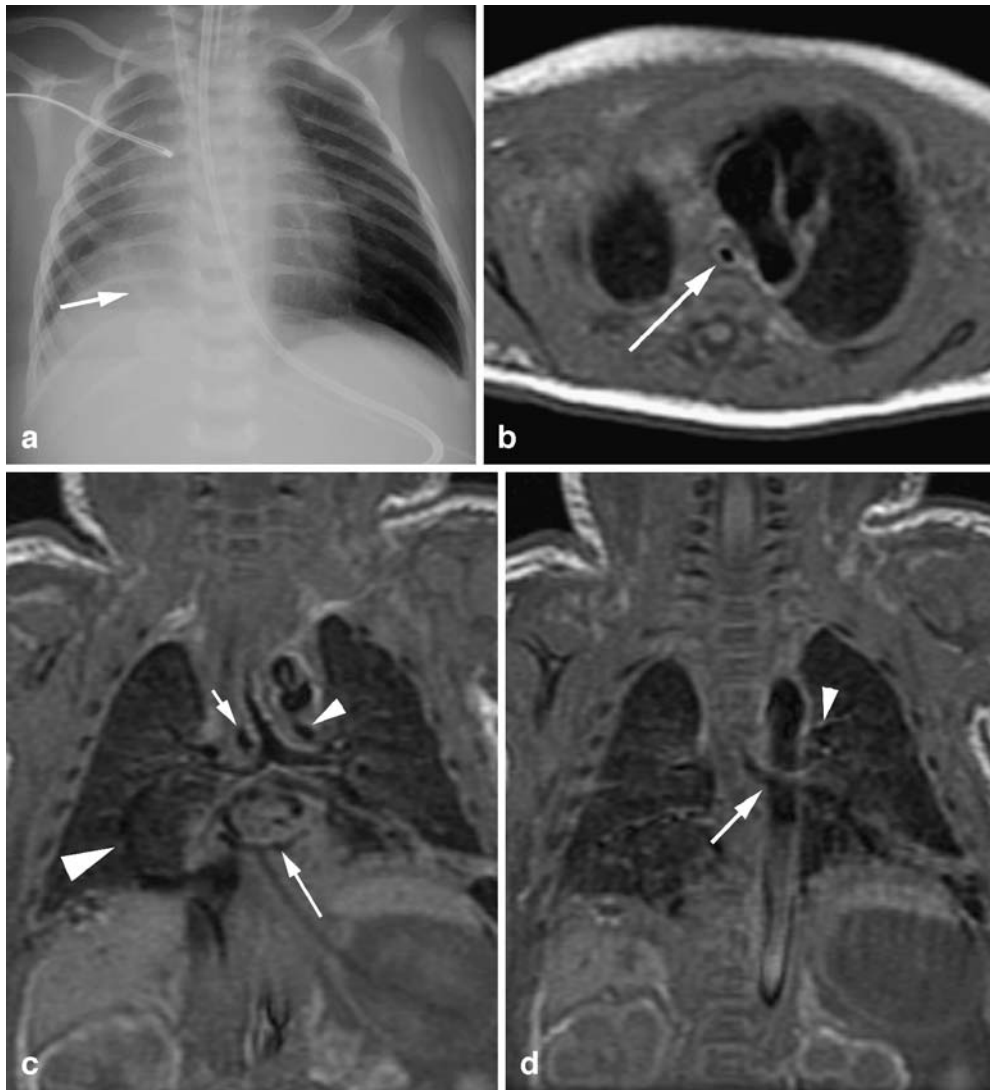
Hypoplastic right lung, partial pulmonary artery sling, tracheal stenosis, scimitar syndrome, horseshoe lung and pulmonary sequestration in a 10-day-old boy with respiratory distress. a Chest radiograph. There is a small-volume hypoplastic right lung with decreased vascular branching and ipsilateral cardiomeastinal shift. There is a curving tubular density in the right lower lung suggestive of a scimitar vein (*arrow*) and moderate right lower lobe opacity. The trachea and bronchi are poorly visualized. b Axial T1-weighted MR image at the level of the aortic arch (left side) demonstrates a narrow trachea (*arrow*). The circular configuration and circumferential signal around the airway suggest stenosis with complete cartilaginous rings. c Coronal T1-weighted MR image. Note the long segment tracheal stenosis and T-shaped low carina characteristic of type II pulmonary artery sling. Normal right (*short arrow*)
